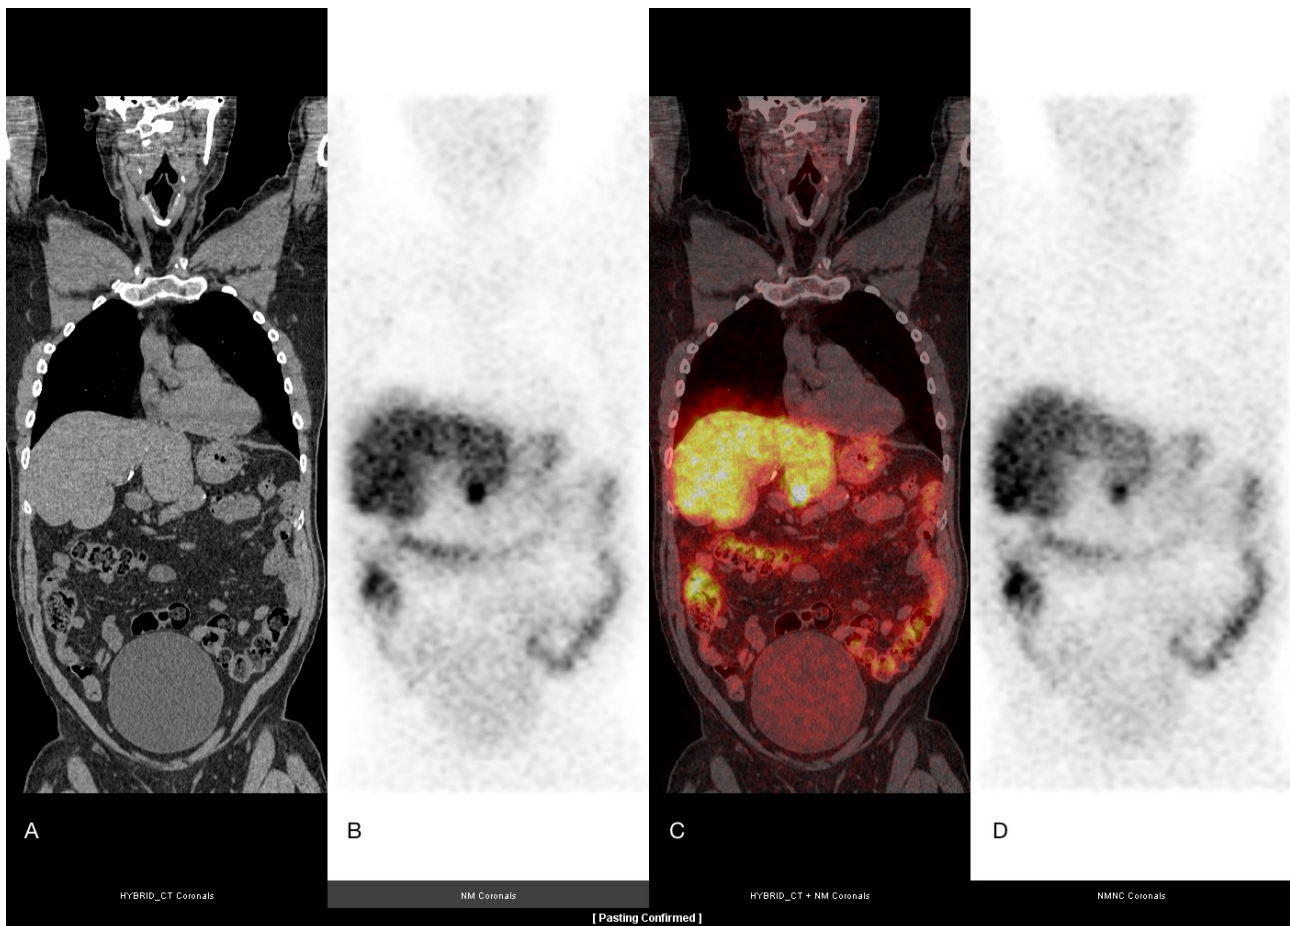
^{177}Lu -DOTATATE SPECT/CT study showing (A) the CT used for localization and AC; (B) AC SPECT; (C) fused CT and AC SPECT; and (D) uncorrected SPECT data.
